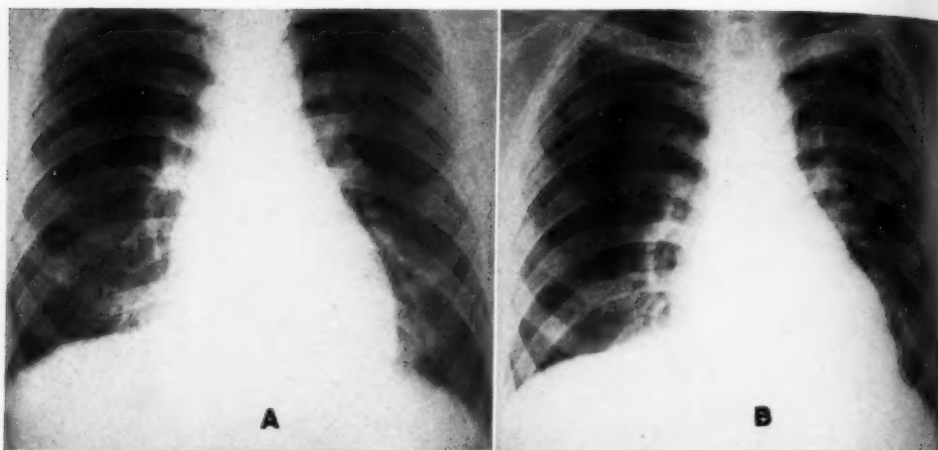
Mitral stenosis of minor degree. A. Roentgenogram made with normal intra-alveolar pressure. B. Roentgenogram made with high intra-alveolar pressure.
